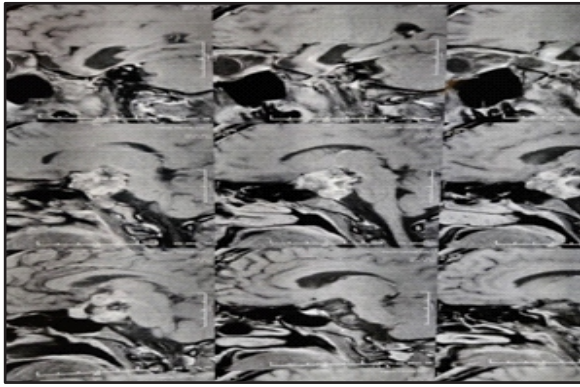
MRI brain showing residual para-sellar mass postsurgery.
